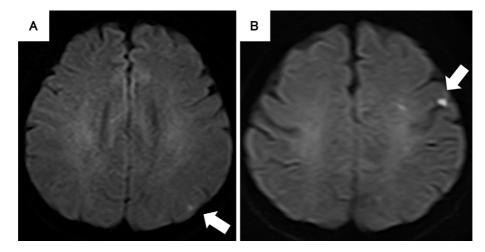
Diffusion-weighted imaging of brain magnetic resonance imaging (MRI). (A) was taken on admission and (B) on day 7 of hospitalization. MRI revealed hyperintense lesions in the left parietal lobe (A, arrow). Despite the treatment, a new cerebral infarction in the left frontal lobe appeared (B, arrow).
